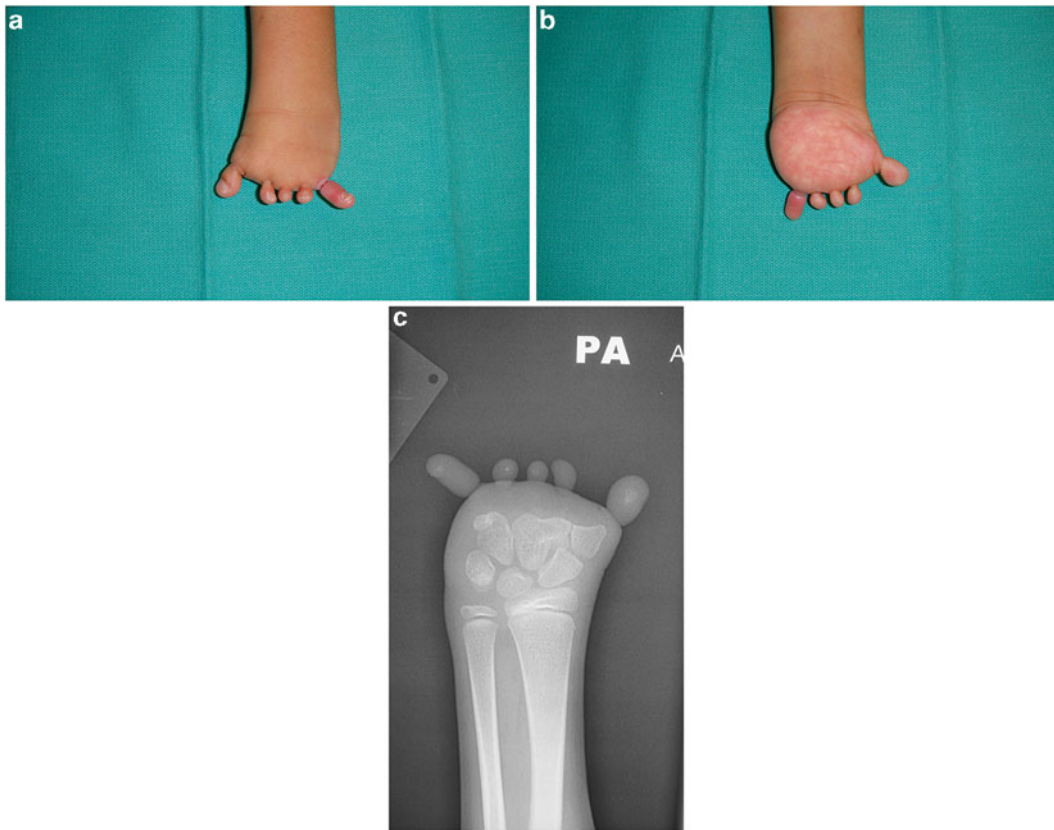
(a–c) Dorsal and palmar photographs and radiograph of a 2-year-old girl with adactylic type IV symbrachydactyly of her left hand. All five digits are represented just by nubbins and are missing
